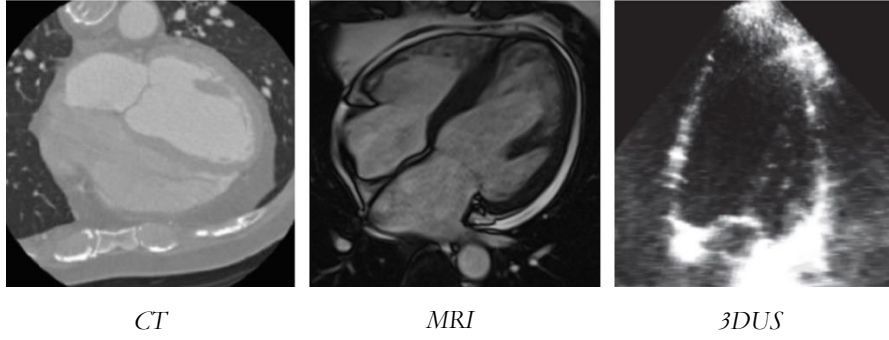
Cardiac images from different modalities. CT = Computed Tomography; MRI = Magnetic Resonance Imaging; 3DUS = Three-dimensional ultrasound.
